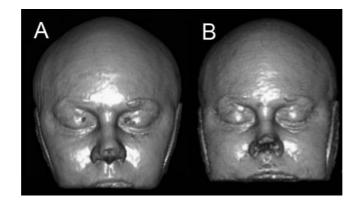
Three dimensional reconstruction of MRI data A) before correction for spatial distortion and B) after correction. The volume reconstruction after correction is a more accurate representation of the subject's head shape.
